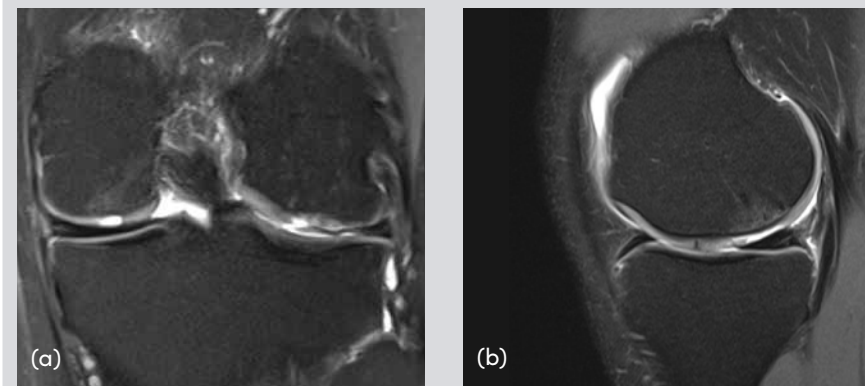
MRI of left knee before surgery with visible cartilage damage over the medial femoral condyle in the coronal plane (a) and the sagittal plane (b).
